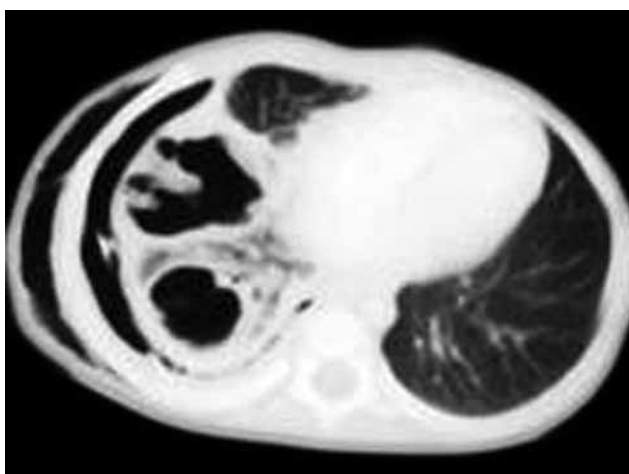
Thoracic computed tomography indicating the appearance of multiple cavities and pleural thickening in the right lung.
